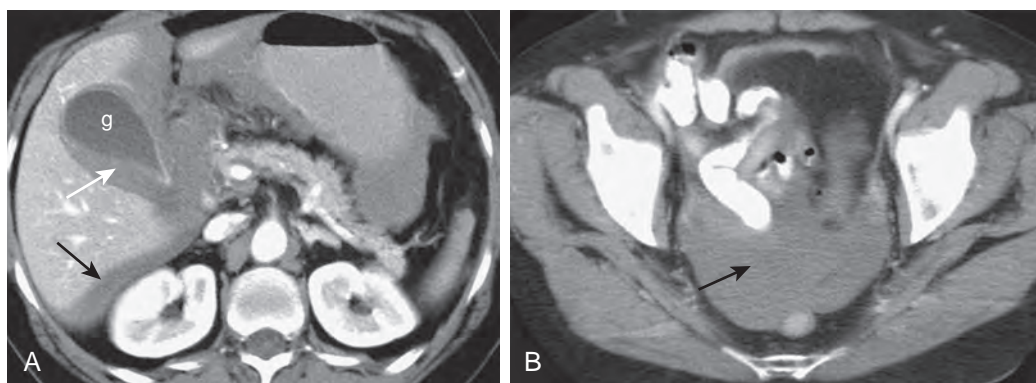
Hemorrhagic cholecystitis: CT findings. A. CT demonstrates distended gallbladder containing layering material of high attenuation corresponding to intraluminal blood (white arrow). There has been perforation of the gallbladder, resulting in hemoperitoneum (black arrow). B. Additional blood is demonstrated in the pelvis (arrow).
